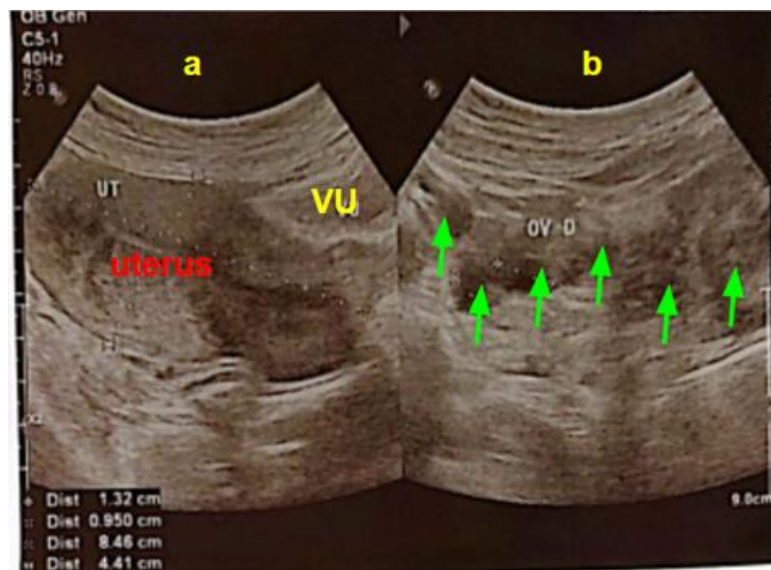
Abdominal Ultrasound Examination Findings
